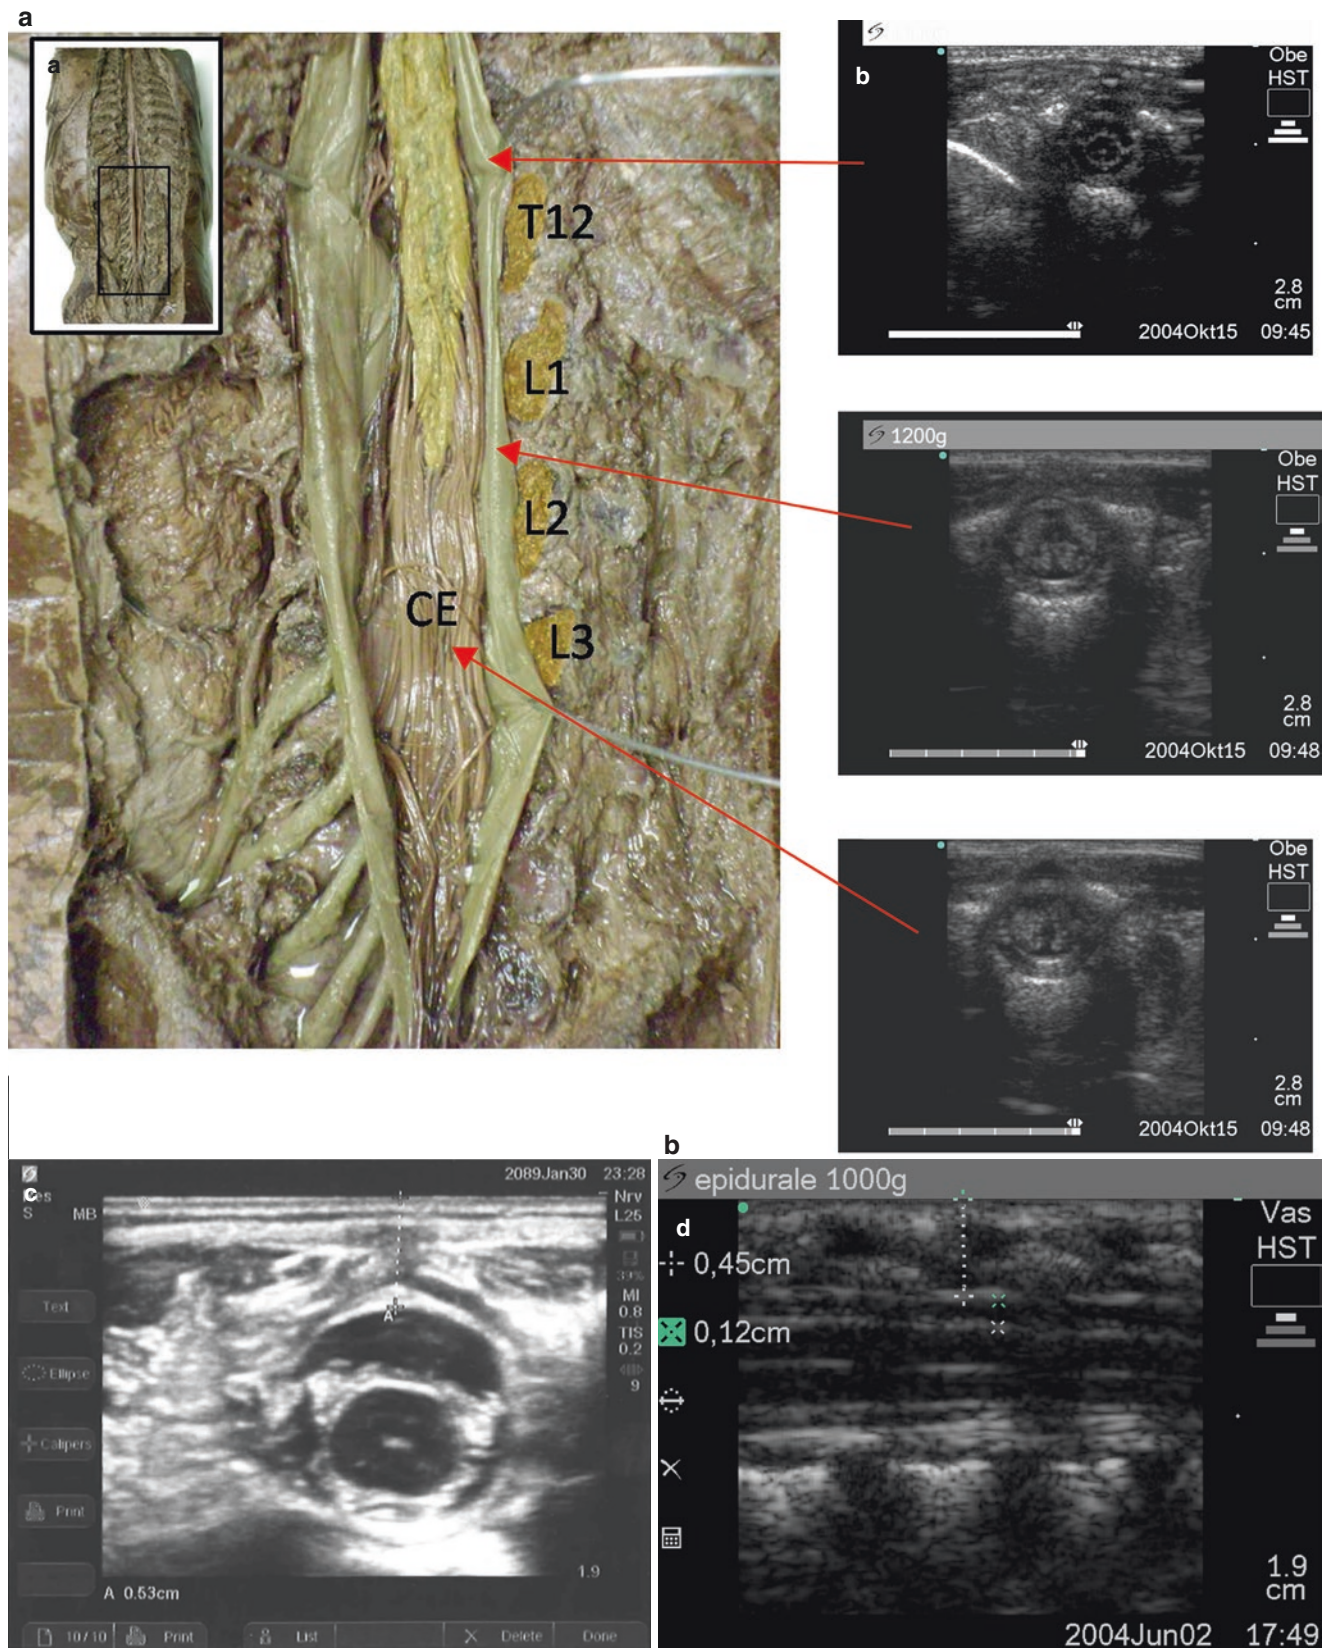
Ultrasound image of the vertebral column (cross section—a; sagittal section—b). The depth the epidural space can be measured before placing the catheter. Abnormalities and normal variants of relevant anatomy can be excluded before placing an epidural block
